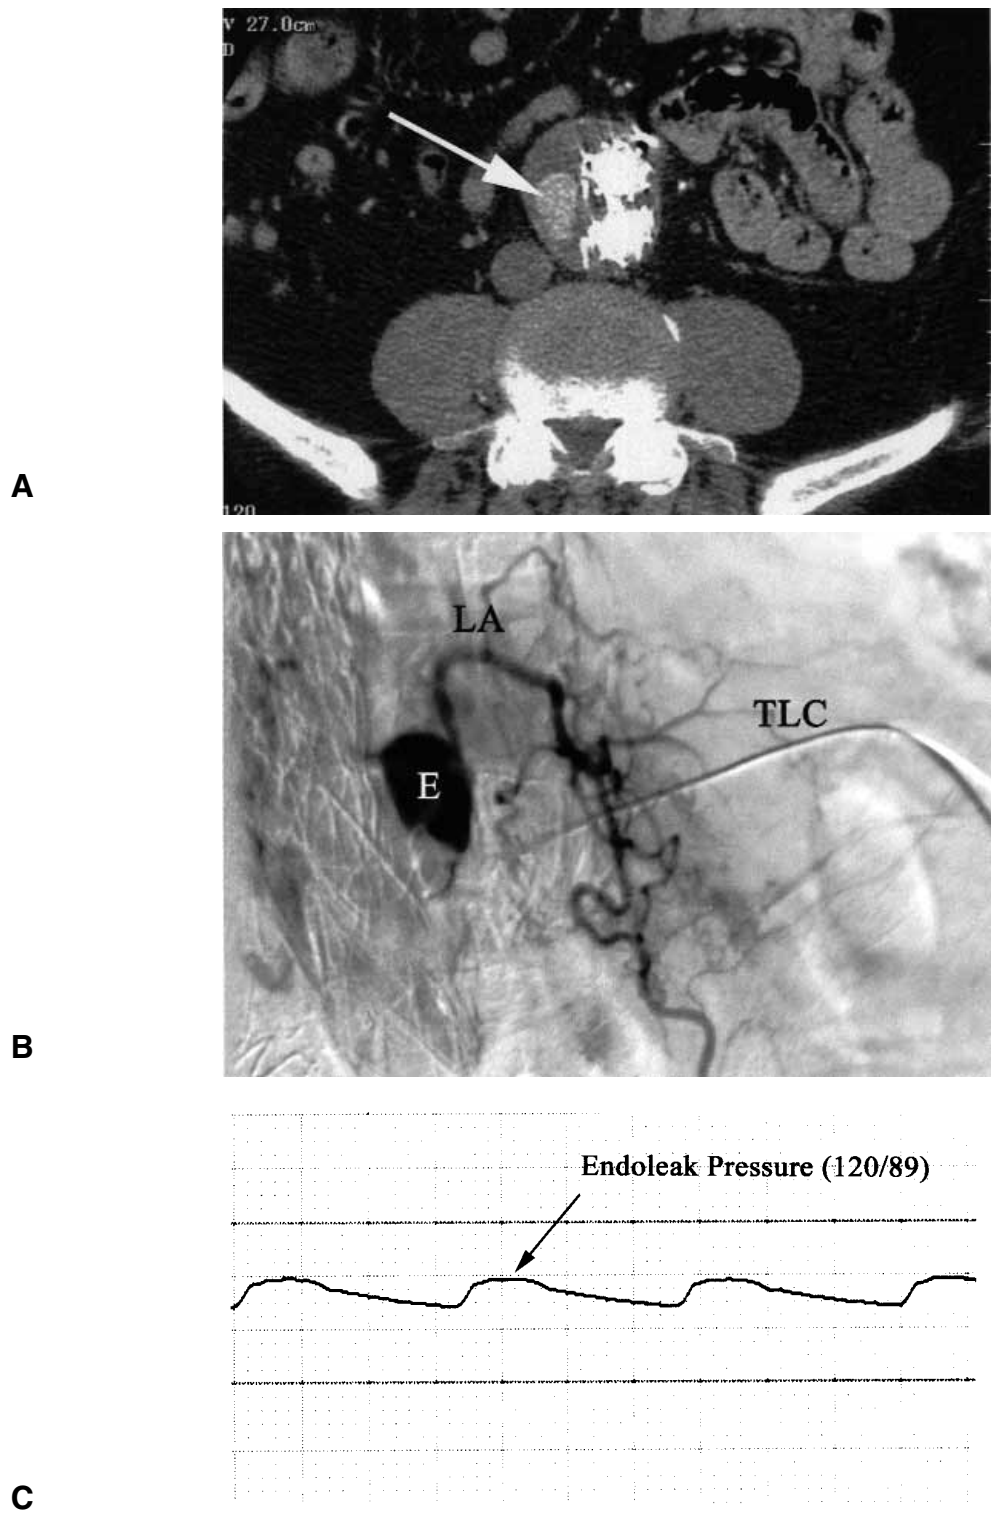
Systemic pressure in a lumbar endoleak through translumbar puncture. A, CT angiography in lower abdomen shows endoleak (*arrow*) in right lateral portion of aneurysm sac. B, Direct translumbar catheterization (*TLC*) and angiography of the endoleak (*E*) show several draining lumbar arteries (*LA*). C, Systemic pressure is measured from within lumbar endoleak.
